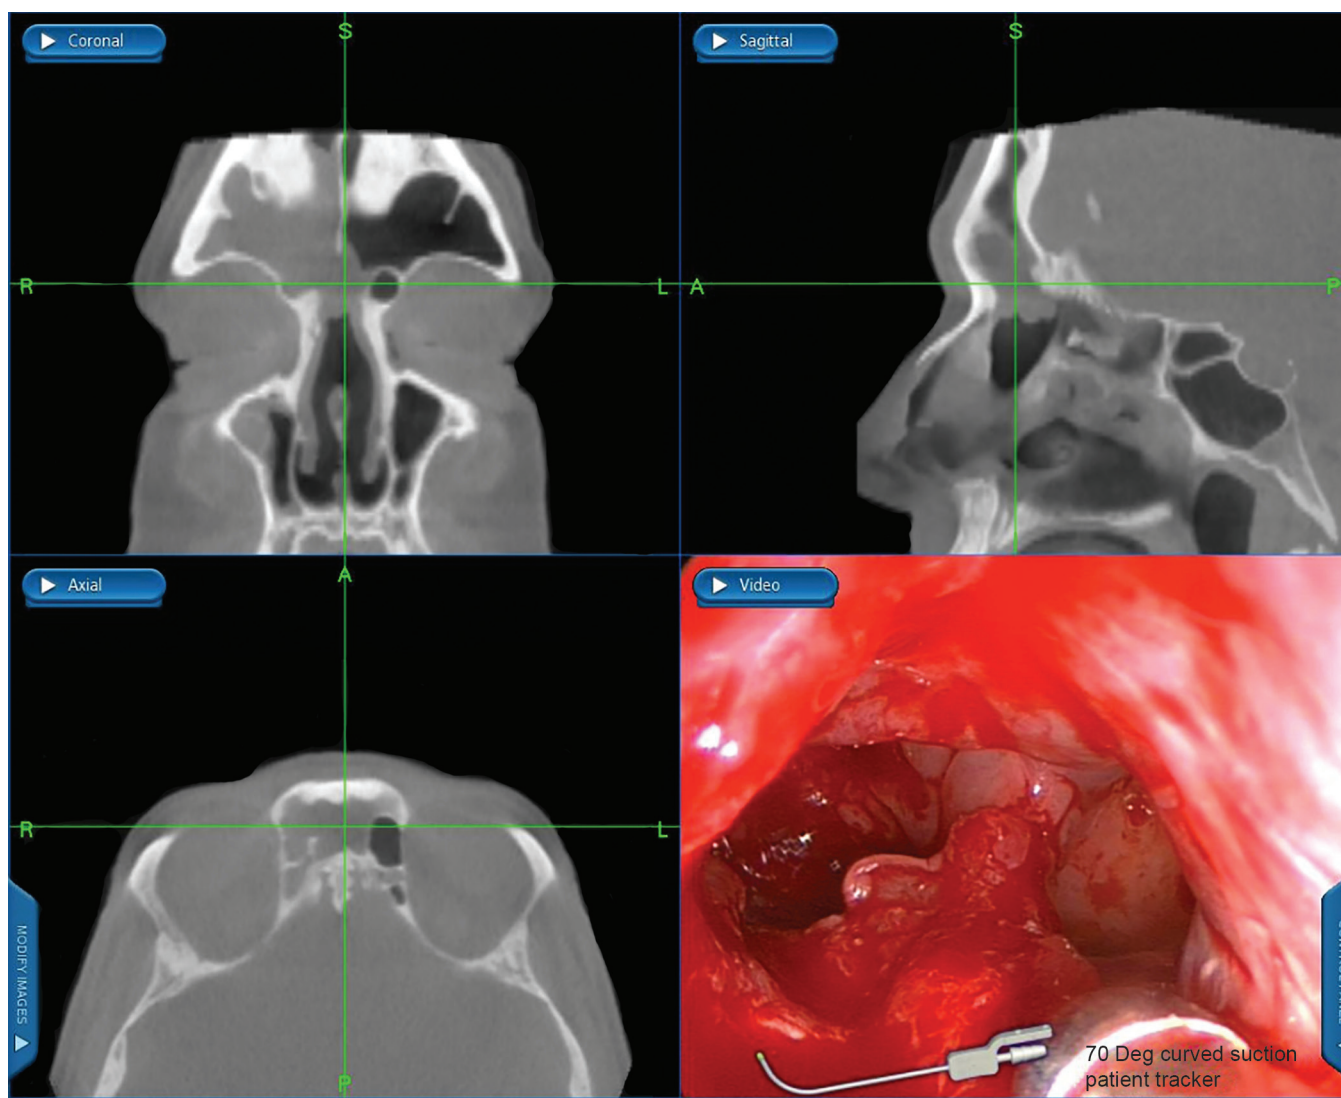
Modified endoscopic Lothrop procedure (Draf III). Computed tomography and endoscopic views demonstrate the creation of a common drainage pathway with drilling away of both frontal sinus floors, removal of the superior nasal septum, and frontal intersinus septum.
